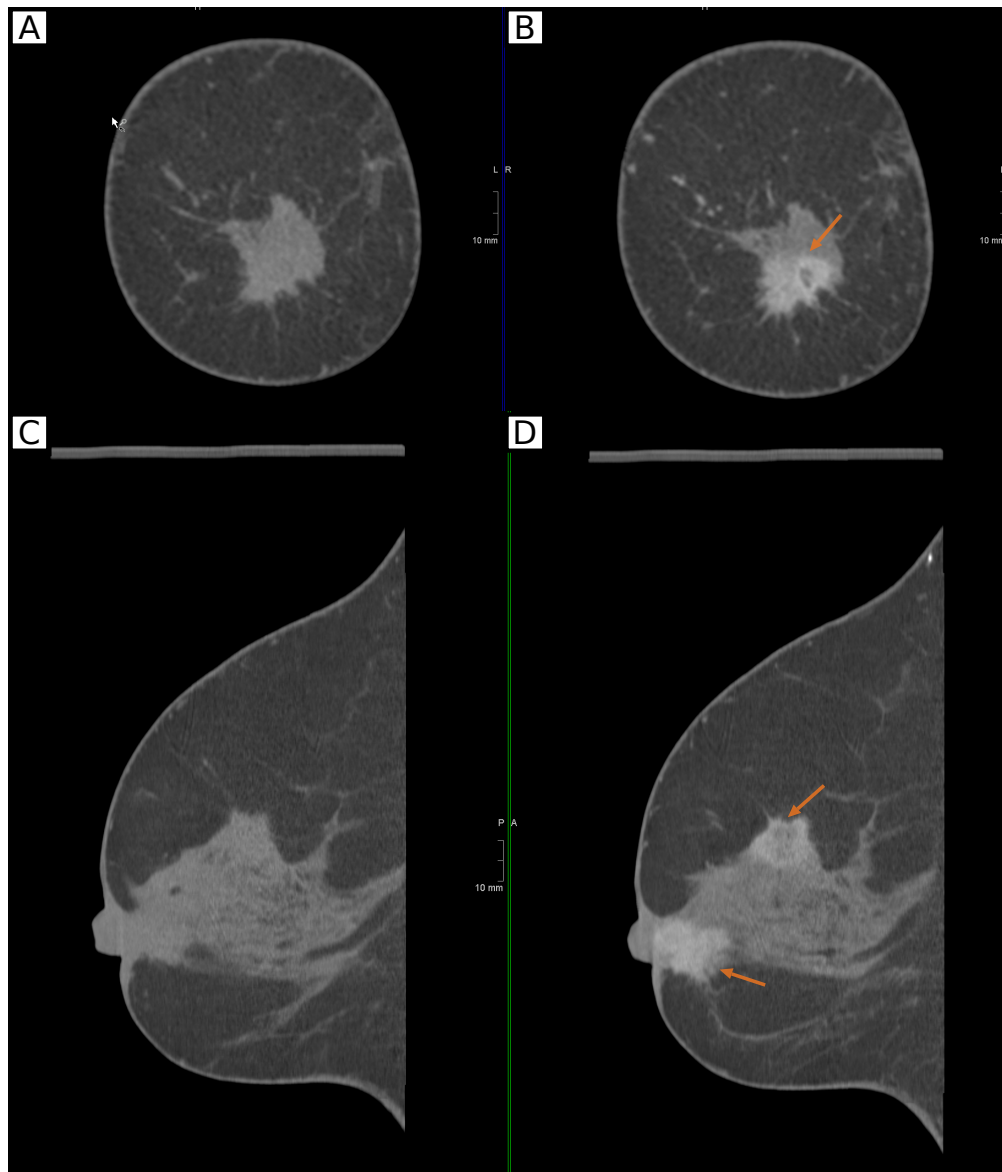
Example of *in vivo* attenuation-contrast breast computed tomography. The (A,B) coronal and (C,D) sagittal views of the uncompressed breast is presented. In contrast to the images in the left column, the images in the right column contain iodinated contrast agent. The patient has a nipple retraction and multicentric invasive ductal carcinoma and was diagnosed with a retroareolar lesion (invasive ductal carcinoma) which is better visible after contrast agent administration. In the sagittal view an additional lesion is detected in the upper quadrants of the breast. Images were provided by Magda Marcon and published in [Heck, 2020].
